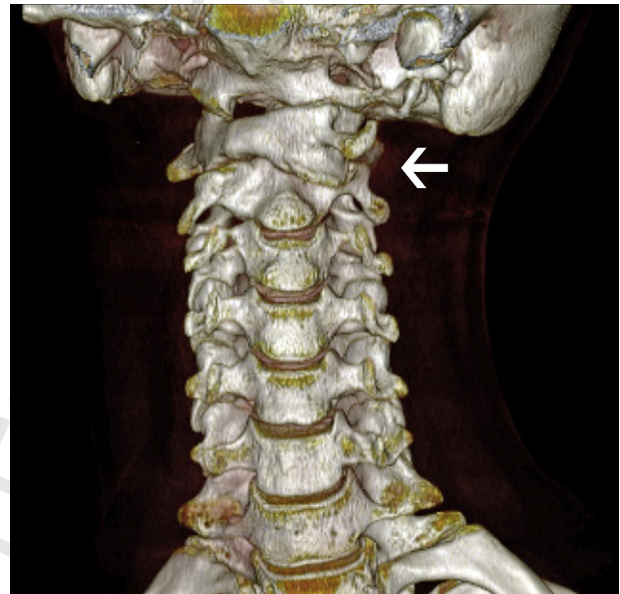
Front view of a three-dimensional computed tomography scan of the cervical spine, showing C1–C2 subluxation (arrows).
